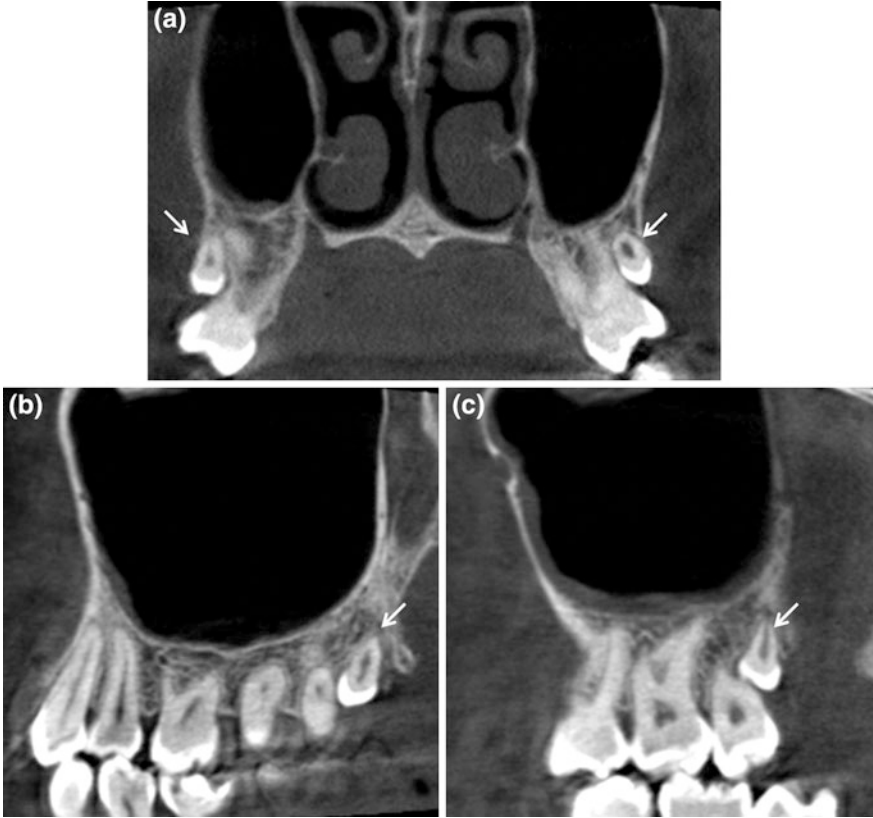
CBCT coronal (a), sagittal (b) and axial (c) sections showing two vertically orientated small supernumerary teeth (*thin arrow*) close to the third upper molars.
